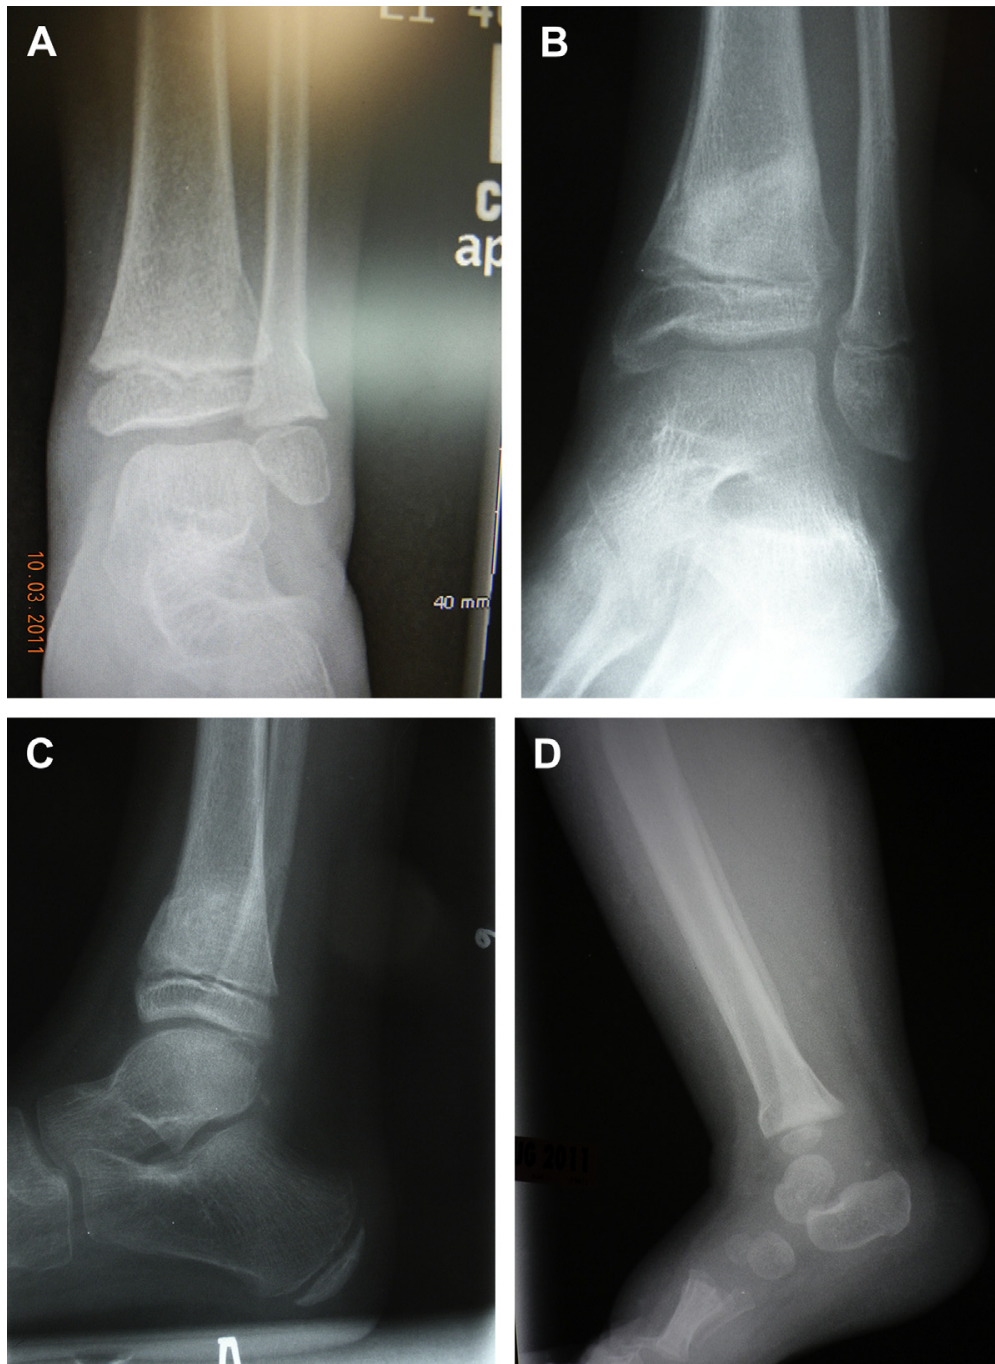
(A) Plastic deformation of tibial and fibular metaphysis. Failure has occurred at the compression side of the bone, designating this as a torus fracture. Minimal displacement of this fracture is noted. Casting is the treatment of choice, and growth interruption is unlikely. (B, C) Typical radiographic findings on anterior-posterior (AP) and lateral views during healing of torus fracture of the tibia in an adolescent. (D) Buckle or torus fracture of the distal tibia in a young patient. Plastic deformation with minimal displacement requires no reduction. The displacement in this case is minimal and is in the plane of joint motion and therefore should be well tolerated.
